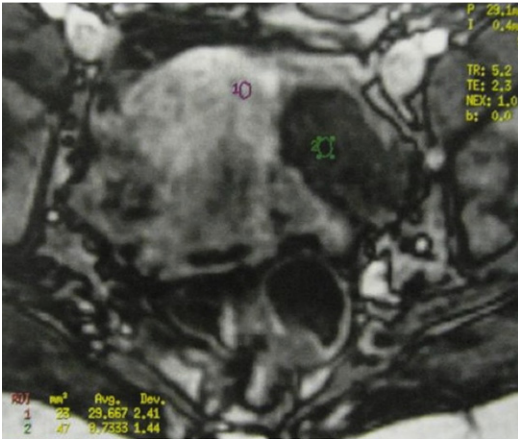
Left adnexal mass. Fibrotecoma. DCE-MR imaging. DCE T1-weighted gradient-echo sequence acquired before, during, and after the bolus injection of gadolinium. As the agent enters into a tissue, it changes the MR SI of the tissue.
